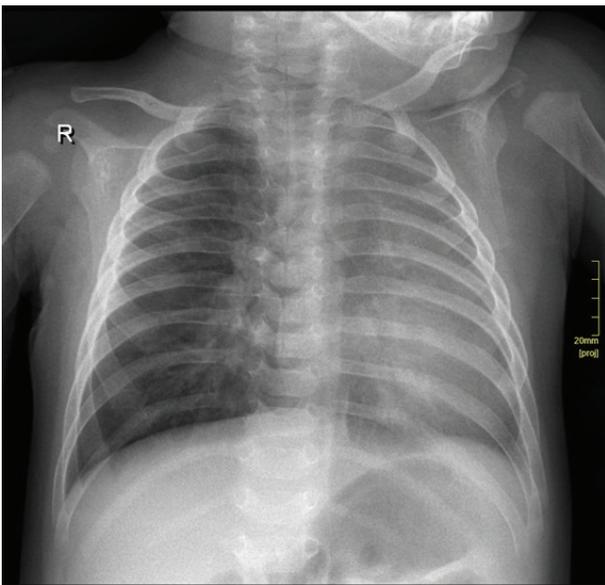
Chest X-ray shows situs solitus, cardiac silhouette shifted to the left. Normal bone structure, no scoliosis, left lung not well aerated-decreased vascularity.
